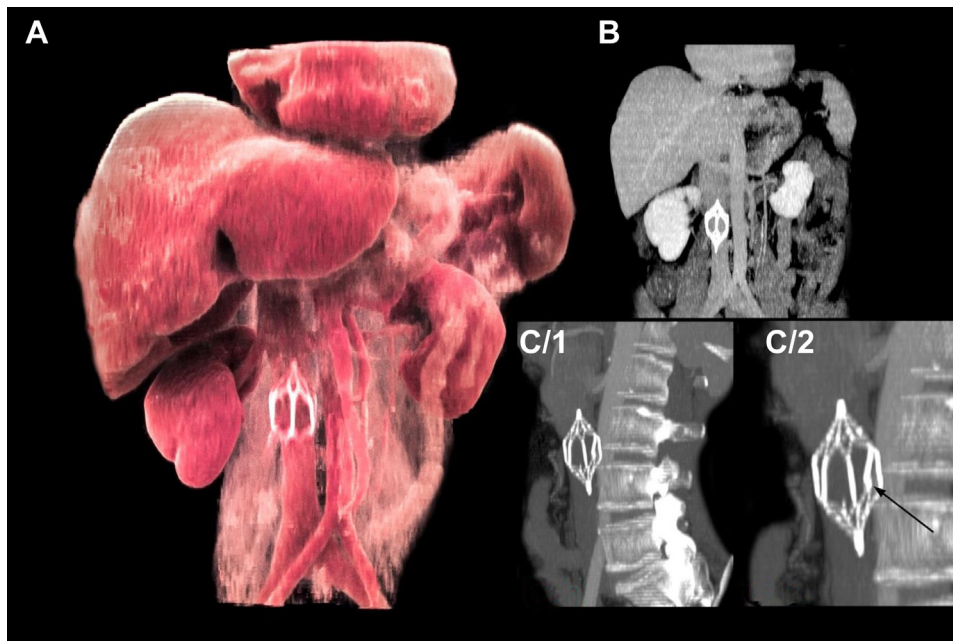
Preoperative imaging studies. A, Coronal view of three-dimensional rendered computed tomography angiogram (CTA) showing the filter situated right below the renal veins. B, Coronal view of maximum intensity projection (MIP) CTA. C/1, Oblique view of thin MIP CTA. C/2, Oblique view of thin MIP CTA at the venous phase suggestive of a posterior strut suspicious for fracture (*black arrow*).
